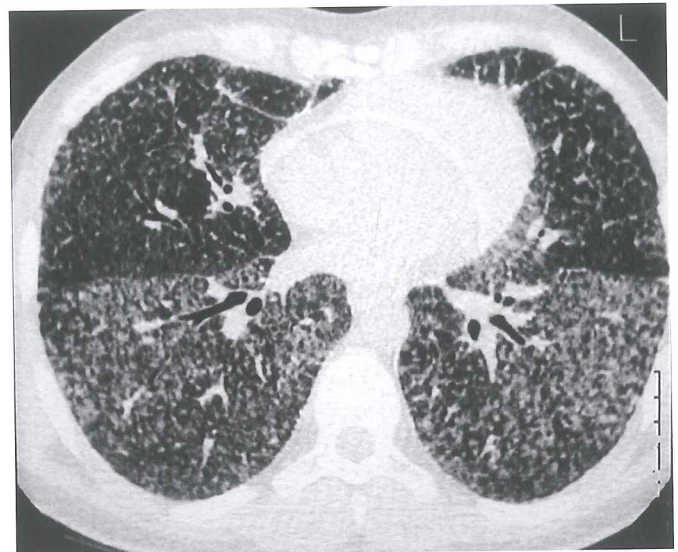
High resolution CT scan showing calcific densities within the lung.
